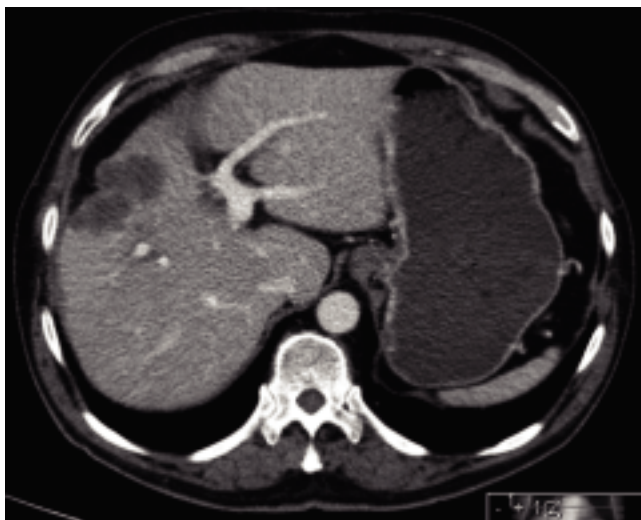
CT image in porto-venous phase showing the gallbladder carcinoma, growing from the gallbladder bed in cranial direction into the liver parenchyma (segment 4a).
